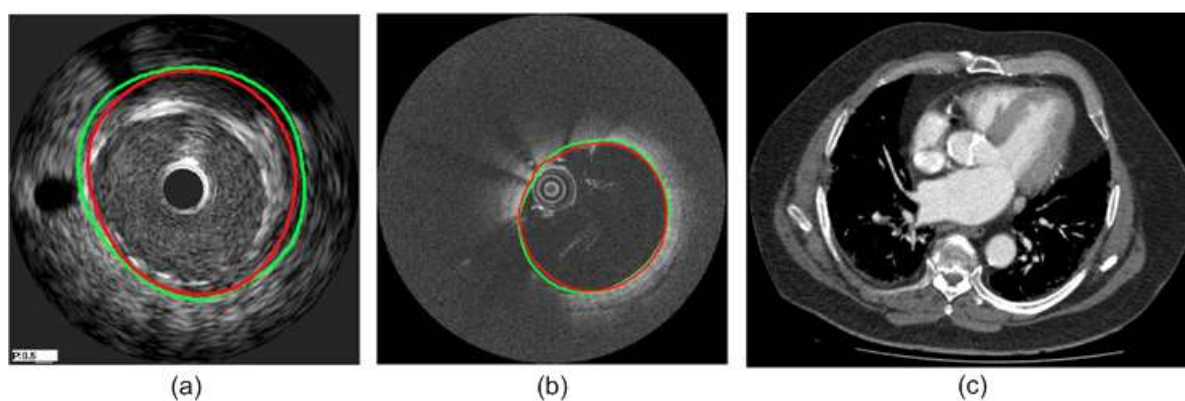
Typical cross-sectional images delivered by different imaging technologies. (a) IVUS image of coronary artery [6], (b) OCT image of coronary artery [6], and (c) X-ray CT image of aortic root (image is from Morriston Hospital [7]).
